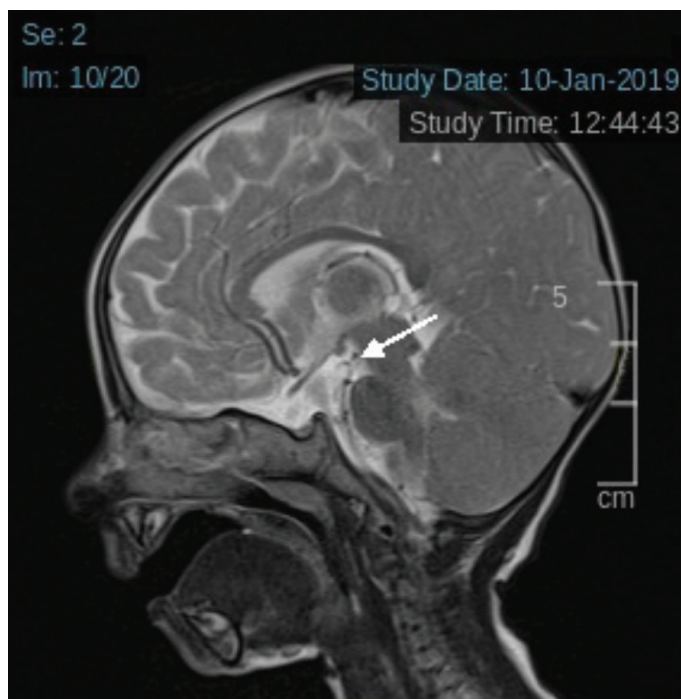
Sagittal magnetic resonance imaging image of the pituitary gland
